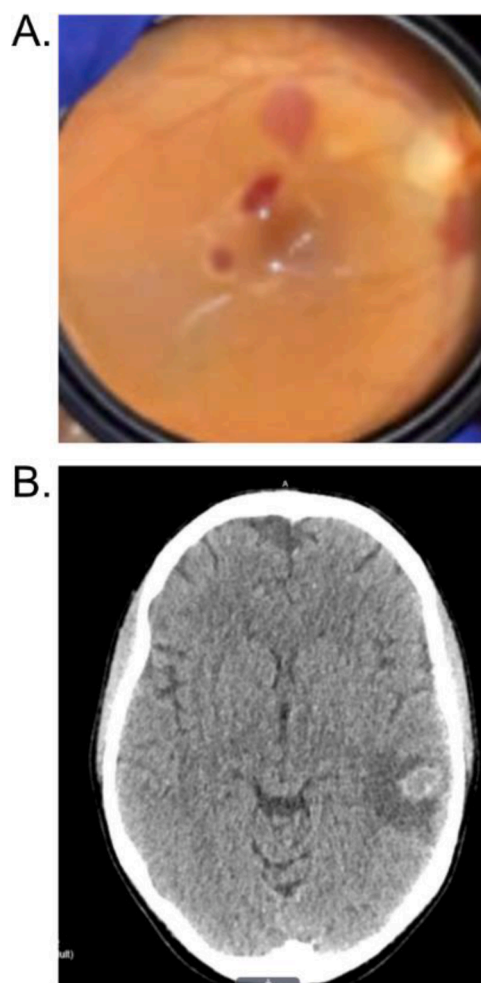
Bedside retinal exam (A) and non-contrasted head CT (B) demonstrating retinal hemorrhages and hemorrhagic lesion with surrounding edema in the temporal lobe of the patient described in case 1. This patient did not experience any residual visual or neurological deficits following their treatment course.
